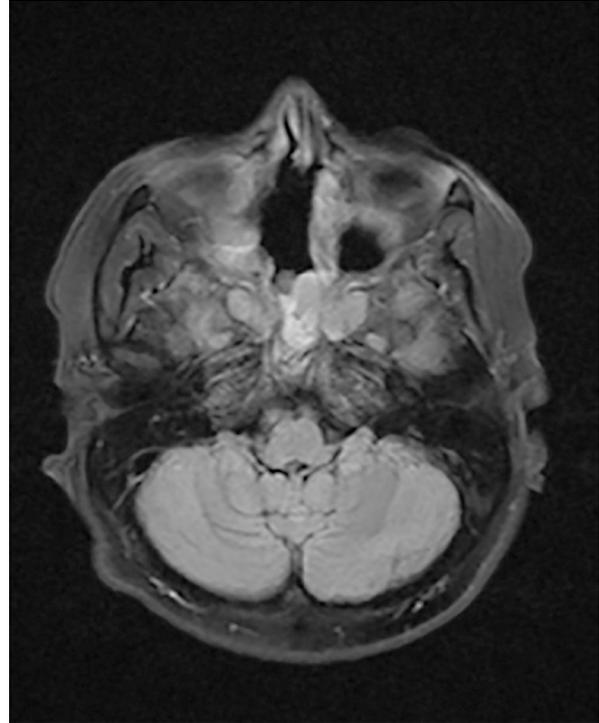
Post-operative head MRI of the patient presented in Figure 1, showing the completely removal of the preoptine cyst.
